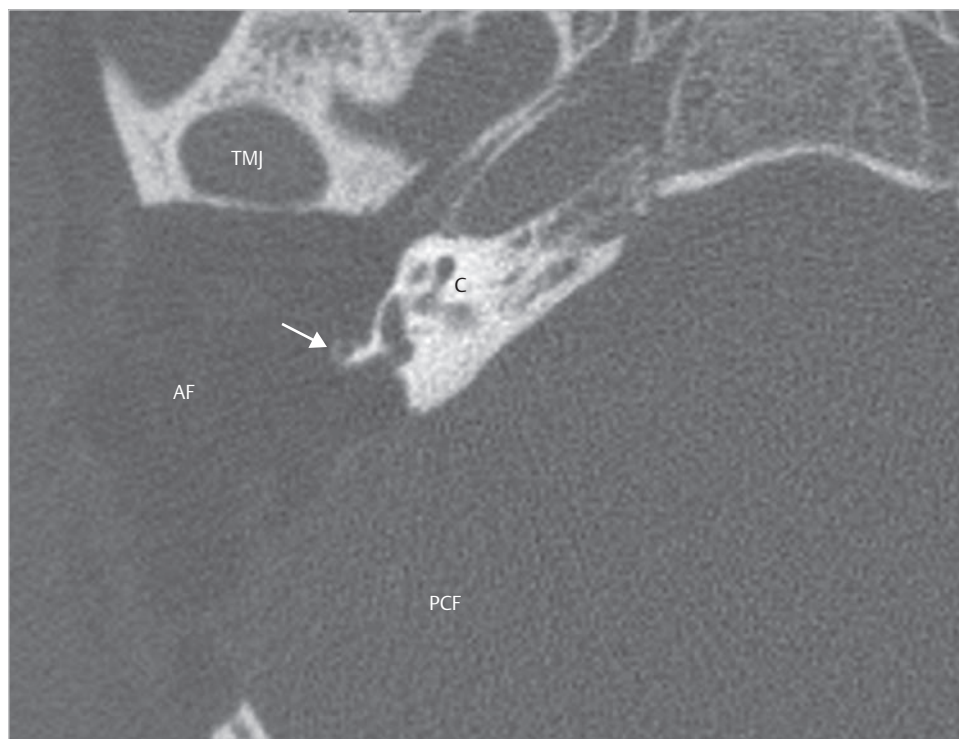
The postoperative axial CT demonstrates extensive removal of the posterior labyrinth. The cochlea partially drilled posterolaterally keeps its shape at this level. The mastoid segment of the facial nerve is identified just posteriorly to the cochlea (*arrow*). AF, abdominal fat; C, cochlea; PCF, posterior cranial fossa; TMJ, temporomandibular joint.
